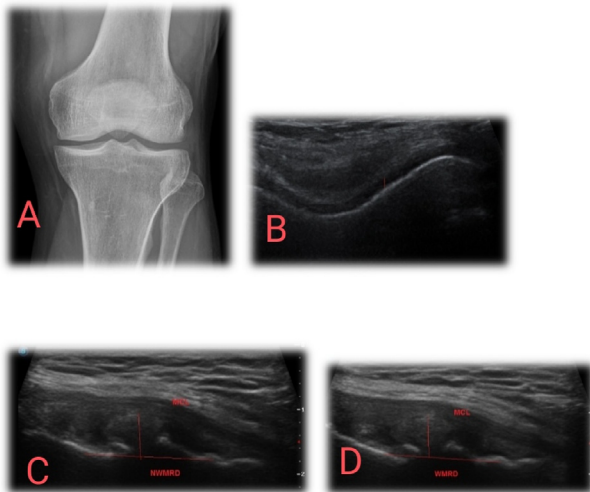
Female patient 50 years old, complaining of pain at the medial aspect of the left knee. (A) Lt knee radiograph AP view KL grade 2 (osteoarthritis) with minimal osteophytes, (B) US of medial compartment in supine position with flexed knee, cartilage thickness of medial femoral condyle = 1.4 mm. (C) US of medial compartment supine position NW-MRD = 5.6 mm. (D) US of medial compartment (standing) W-MRD = 6.8 mm.
